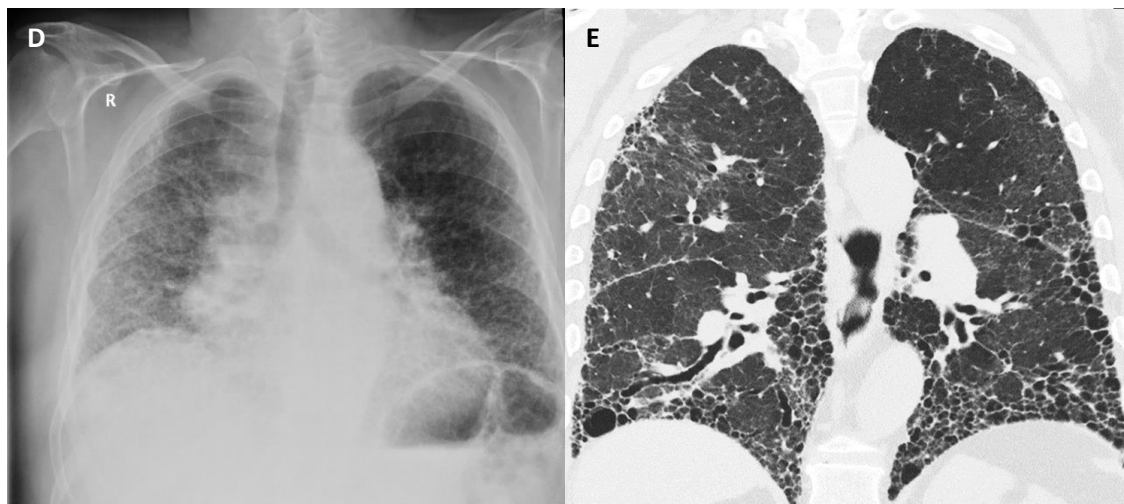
D – Chest X-ray, upright, patient with idiopathic lung fibrosis, reticulonodular interstitial pattern
